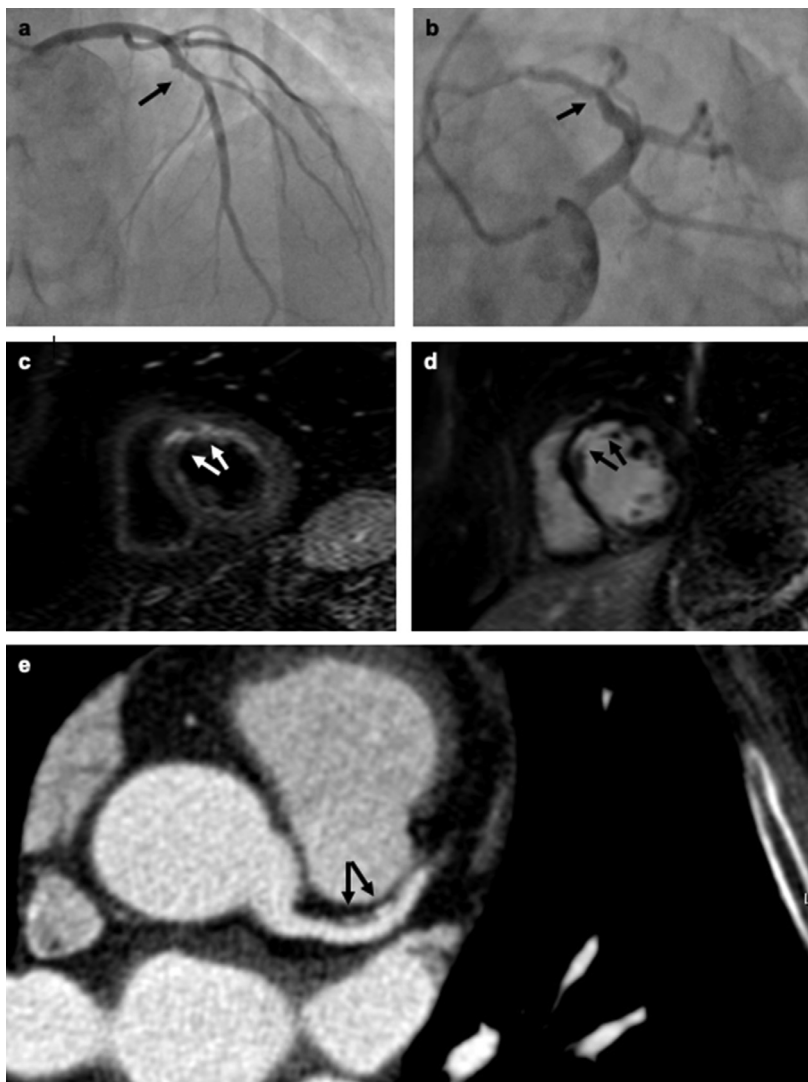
Multimodality imaging approach in a case of type 1 MINOCA. A 54-year-old male presented with chest pain, positive troponin assay and ST-segment elevation in anterior-septal leads. Panels a and b: coronary angiography revealing a non-obstructive ($\leq 50\%$) lesion (arrows) of the proximal left anterior descending (LAD) coronary artery. Panels c and d: contrast enhanced cardiac magnetic resonance imaging (CE-CMR), short-axis views. Panel c: T2 weighed short-tau inversion recovery (T2-STIR) image, showing edema in the basal septal and anterior segments of the left ventricle (arrows). Panel d: phase sensitive inversion recovery (PSIR) image, revealing sub-endocardial scar in the same segments (arrows). Panel e: coronary computed tomography scan confirmed a non-obstructive and mixed atherosclerotic lesion of the proximal LAD (arrows). The patient was treated with aspirin, clopidogrel, atorvastatin, metoprolol, and zofenopril.
